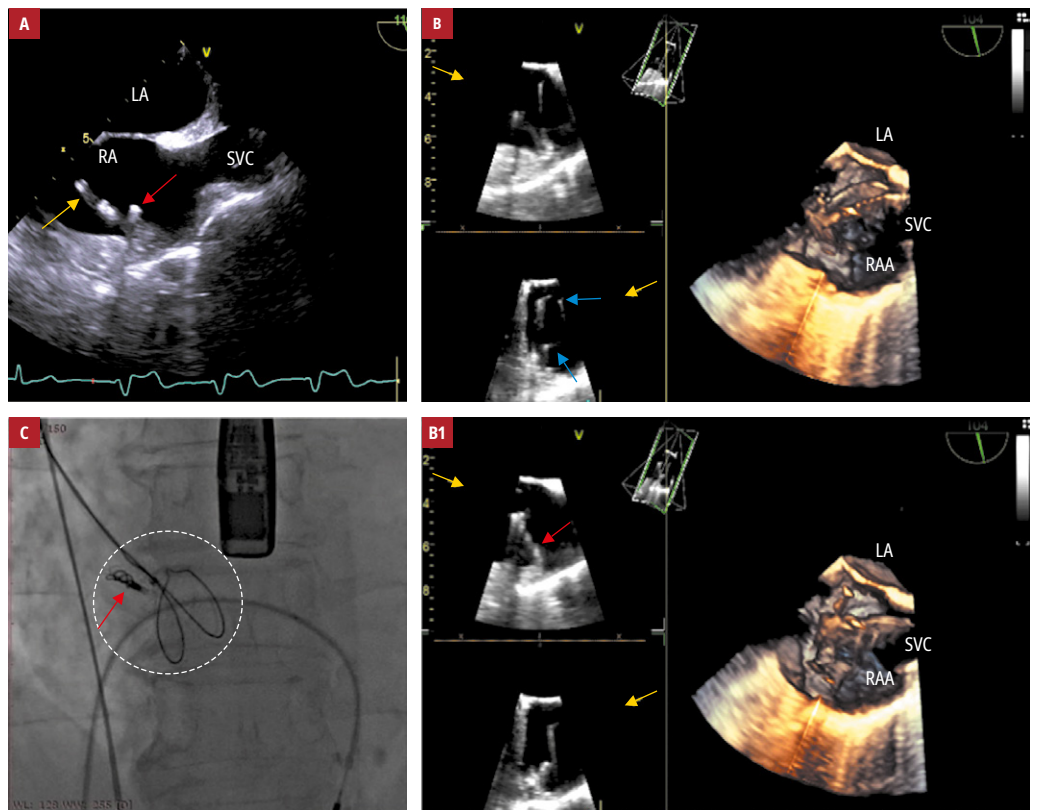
Attempted removal of the lead remnant using a lasso sheath: A – transesophageal echocardiography (2-dimensional, bicaval view) showing a fragment of the broken lead tip (red arrow) and the silicon tube (yellow arrow) in the right atrial appendage; B – transesophageal echocardiography (3-dimensional, bicaval view) showing grasping the broken pieces (A) with a lasso sheath (blue arrows). The tightened lasso loop around the target piece is shown on panel B1; C – fluoroscopy showing the broken lead (arrow) and the lasso sheath (circle)
